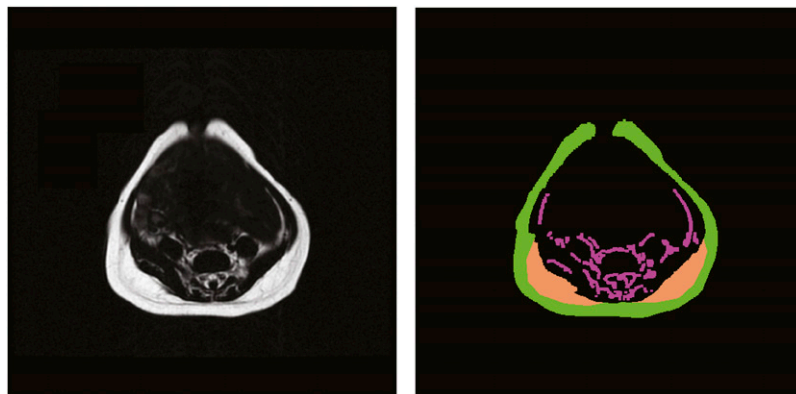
Original abdominal water-suppressed MRI (left) and the results of the segmentation of abdominal adipose tissue compartments (right). Each compartment is filled with a different color as follows: green denotes superficial subcutaneous tissue, orange denotes the right and left deep subcutaneous tissue, and magenta denotes the internal adipose tissue.
